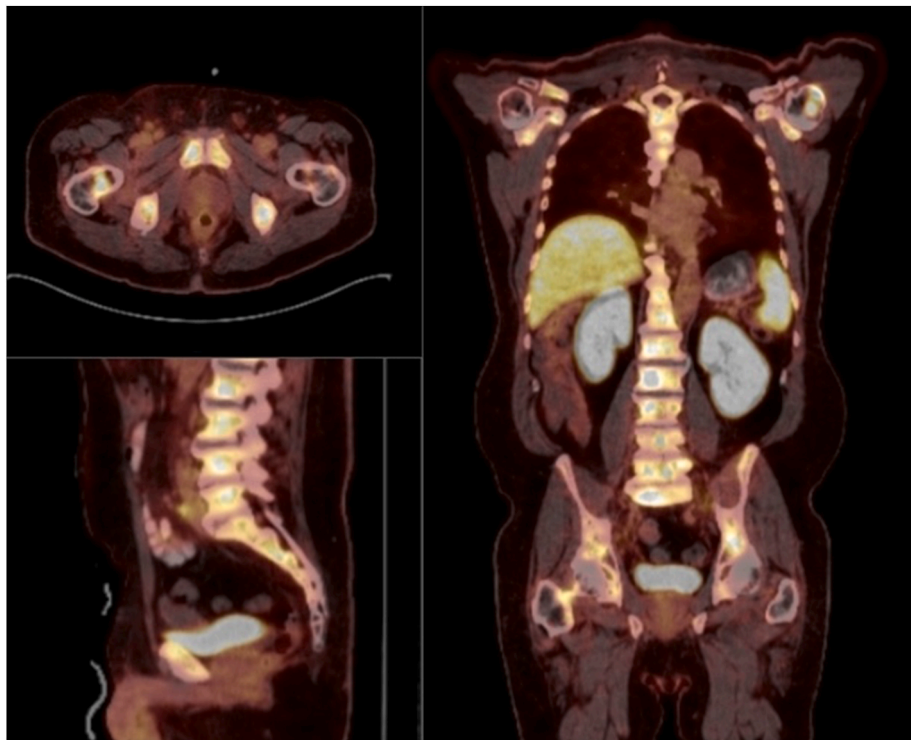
Positron emission tomography (PET) of prostate specific membrane antigen (PSMA) with transverse (top left), sagittal (bottom left), and coronal (right) views.
